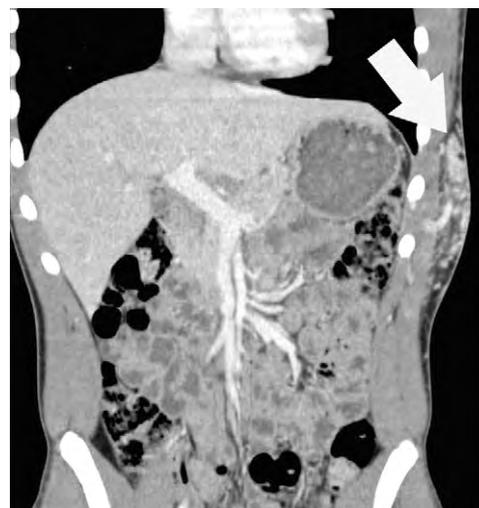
Arteriovenous malformation in a 16-year-old male patient with a left chest wall mass. Contrast-enhanced coronal reconstructed CT image demonstrates a cluster of enhancing vessels in the chest wall (arrow).
